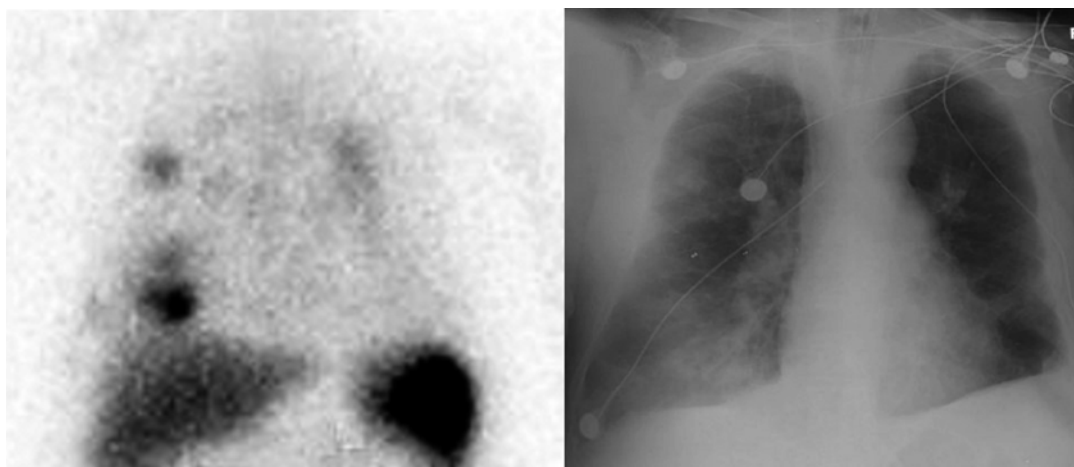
Bilateral, multifocal areas of pulmonary activity are present on the ^{111}In -labeled leukocyte image of a patient with pneumonia (*left*). Bilateral infiltrates are present on the chest x-ray performed the same day (*right*)
